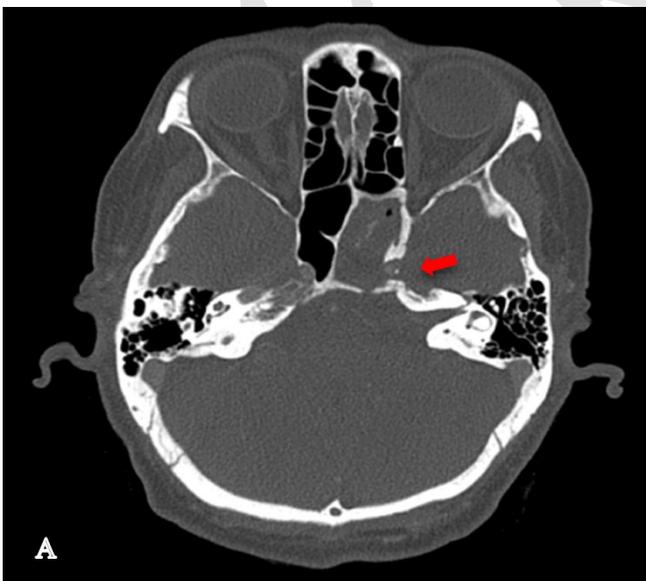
Axial CT image (A) shows isolated left sphenoid lesion with calcification within, and hyperostosis of left sphenoid sinus wall with erosion.
